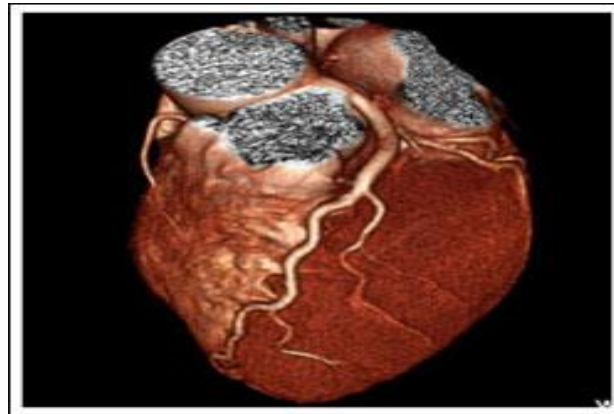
Sample of image taken by 64 slice CT
